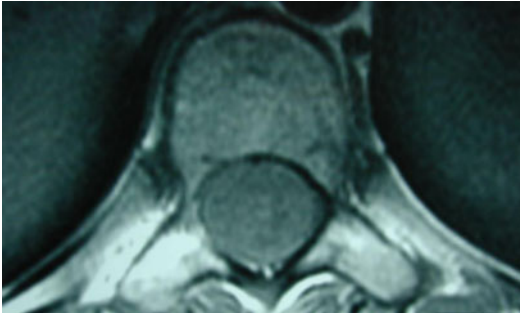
T1-weighted MRI of spinal cord ganglioglioma, axial view: MRI is the study of choice to assess the characteristics of spinal cord tumors, though the radiological features are usually non-specific. T1-weighted MRI may demonstrate hyper-intense, hypo-intense, or even irregular signals
